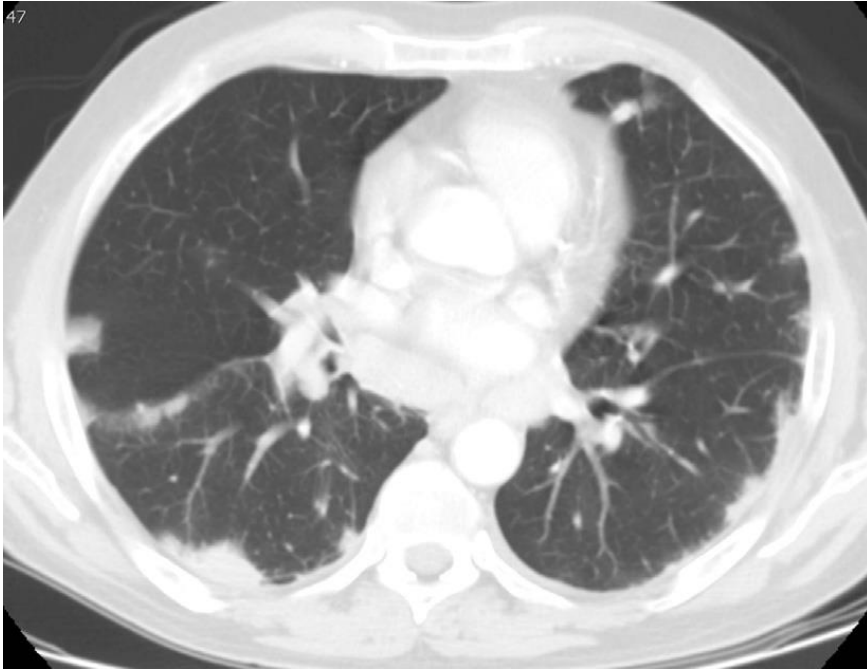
Peripheral nodules and consolidation in 69-year-old man with IgG4-RD. Chest CT axial scan at the level of the aortic root on lung windows. There are multiple, bilateral peripheral lung nodules and consolidative opacities that also extend along the right major and minor fissures, in a perilymphatic distribution that is characteristic of IgG4-RD. The patient denied pulmonary symptoms.
